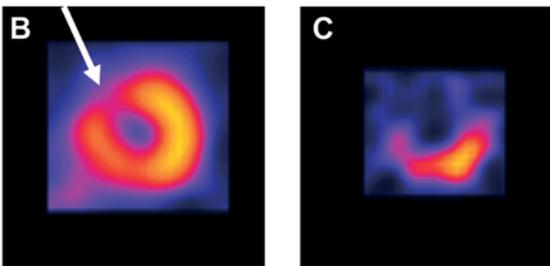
Viability assessment with FDG SPECT
